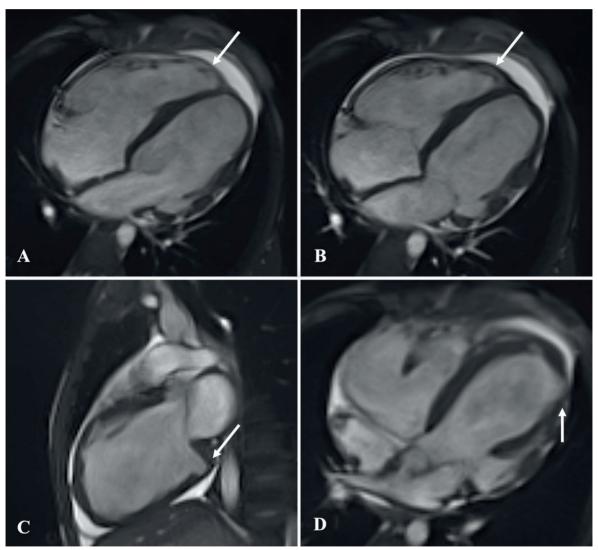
Cardiac magnetic resonance imaging of the patient showing hypokinesia: A: bulging in the RV at the end of systole; B: bulging in the RV at the end of systole; C: bulging in the RV at the end of systole; D: Bulging in the LV at the end of systole. Arrows indicate the point of bulging.
